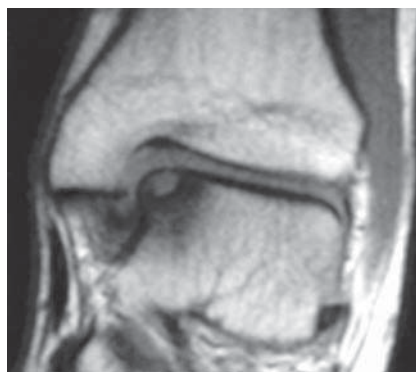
T1-weighted coronal MRI scan of the ankle showing an osteochondral lesion of the medial part of the talus. (Reproduced from Schachter AK, Chen AL, Reddy PD, Tejwani NC: Osteochondral lesions of the talus. *J Am Acad Orthop Surg* 2005;13:152-158.)
